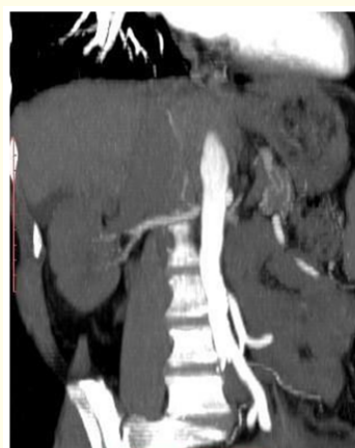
Coronal CT scan. Note the missing right artery origin due to stenosis.
